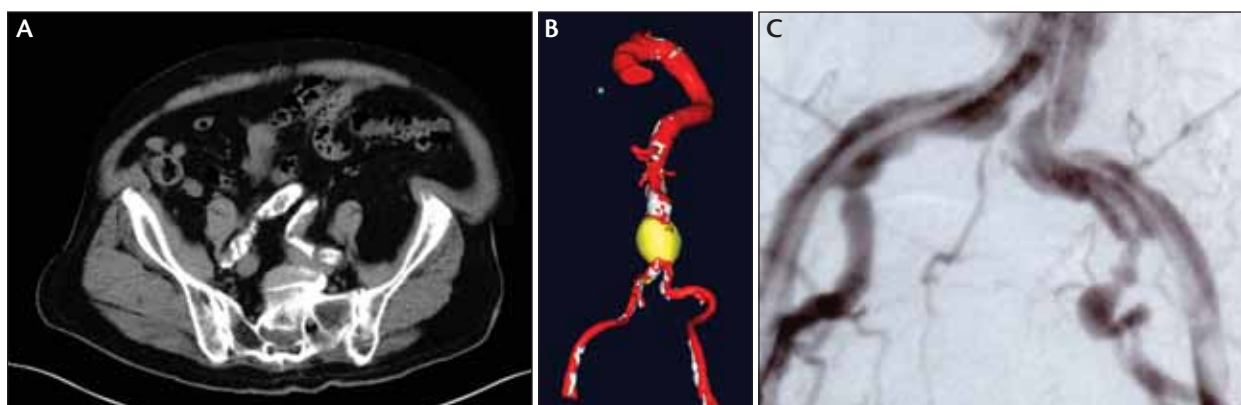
Tortuosity and significant calcification of the access vessels as seen on a representative slice of the unenhanced axial computed tomographic angiogram (A), three-dimensional reconstruction (B), and conventional angiogram (C).
